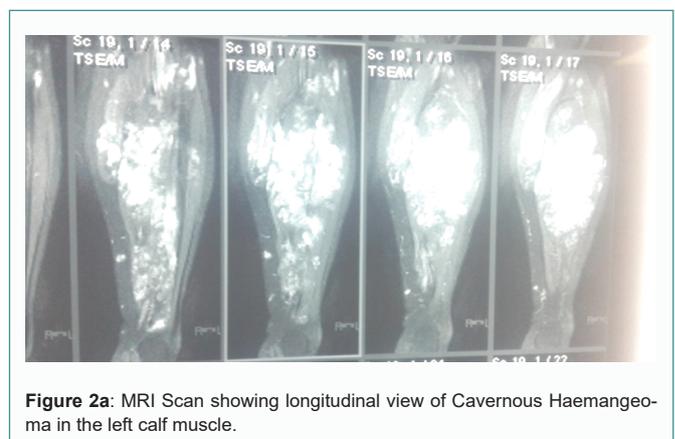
MRI Scan showing longitudinal view of Cavernous Haemangioma in the left calf muscle.
